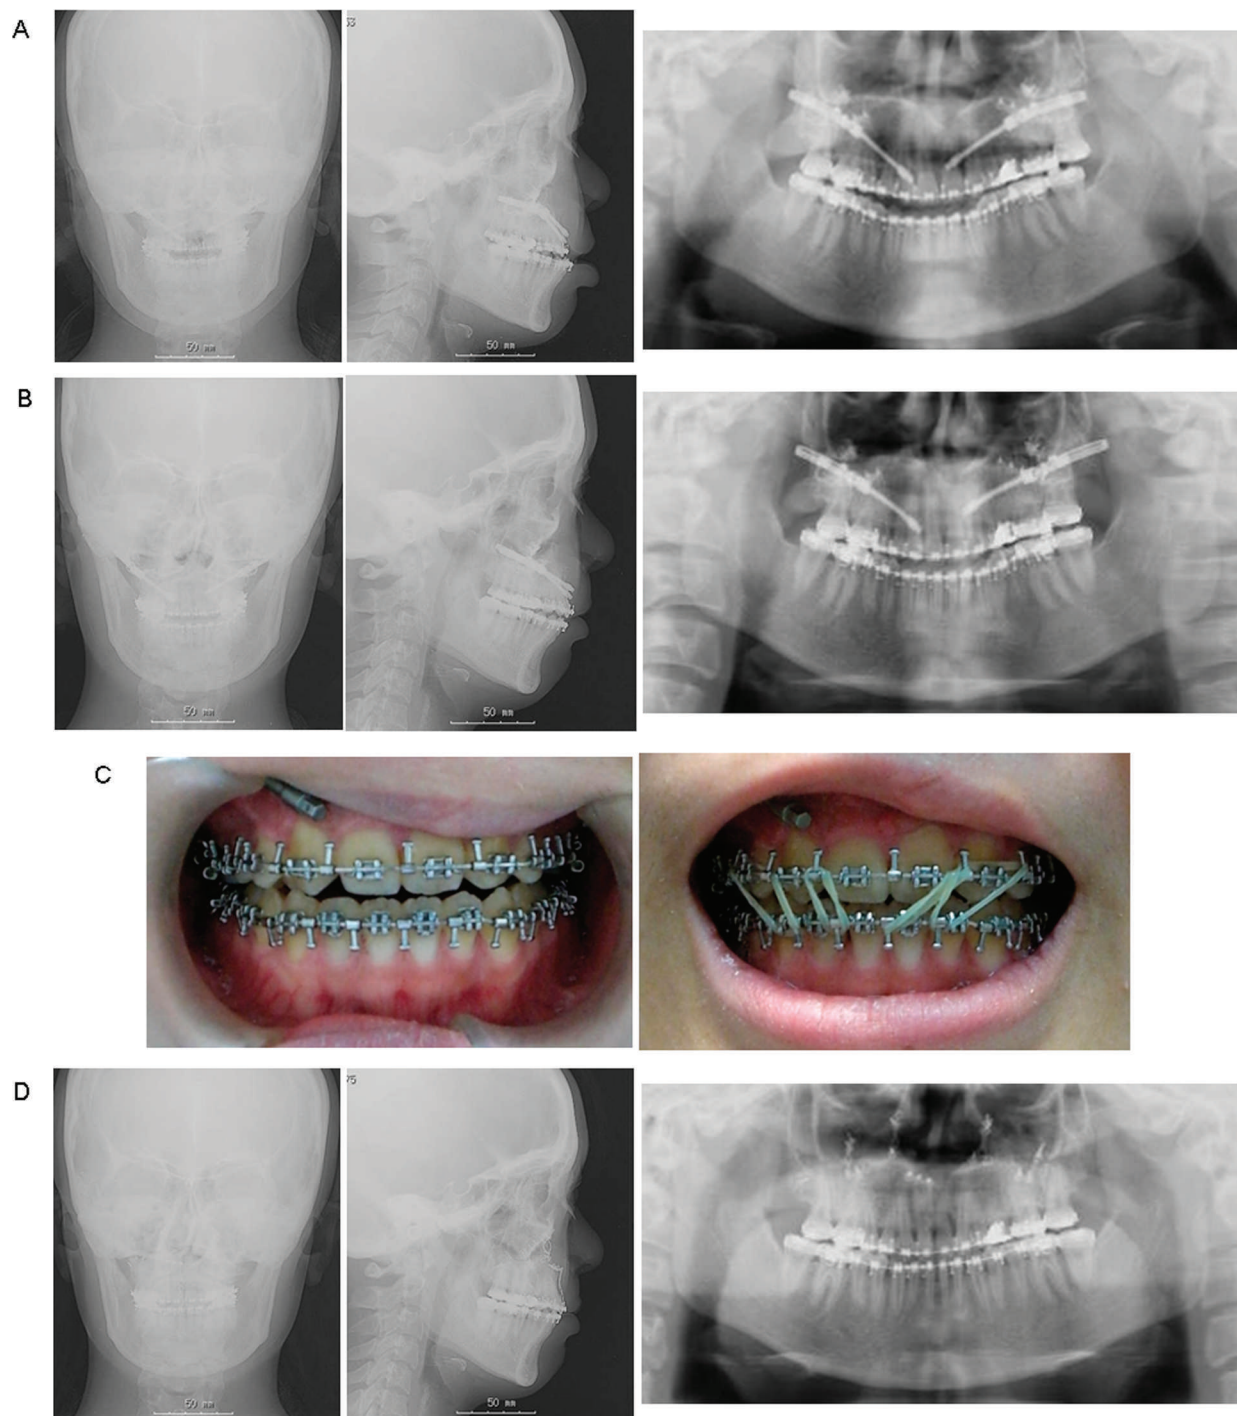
Cephalograms and panoramic radiographs during distraction, and intraoral photographs after distraction. (A) During advancement. (B) After advancement. (C) Orthodontic elastic traction after advancement. (D) 2 months after advancement.
